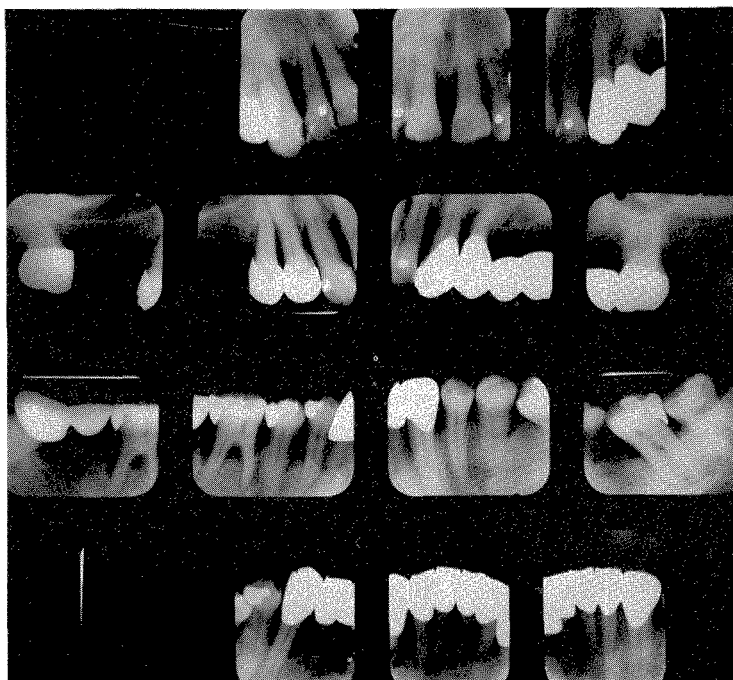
Roentgenograms taken in 1946. The bone destruction was progressive.
